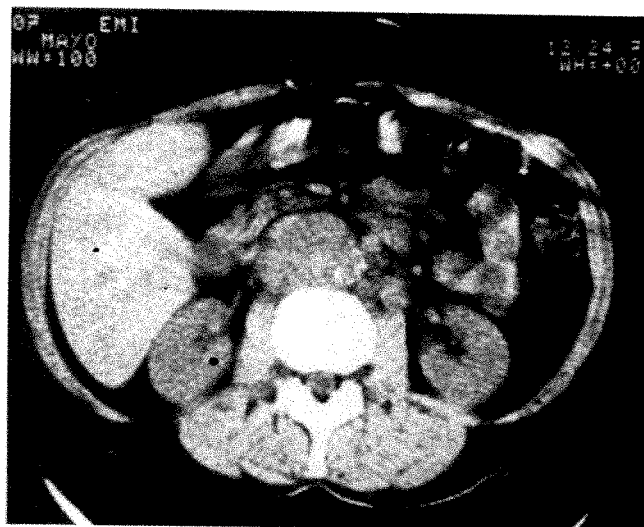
CT scans of 55-year-old woman with pruritis and mild jaundice. Clinical differential diagnosis included hepatitis and obstructive jaundice. *A*, Dilated hepatic ducts in region of porta hepatis, right lobe, and left lobe. Distal pancreas is of normal size but contains dilated pancreatic duct. *B*, Rounded, dilated ducts in right lobe of liver, dilated gallbladder, and dilated pancreatic duct in normal-sized pancreas. *C*, Head of pancreas normal in size but containing dilated pancreatic duct and common bile duct. Gallbladder also dilated. Carcinoma of ampulla of Vater (1.5 cm in diameter) removed at operation.
